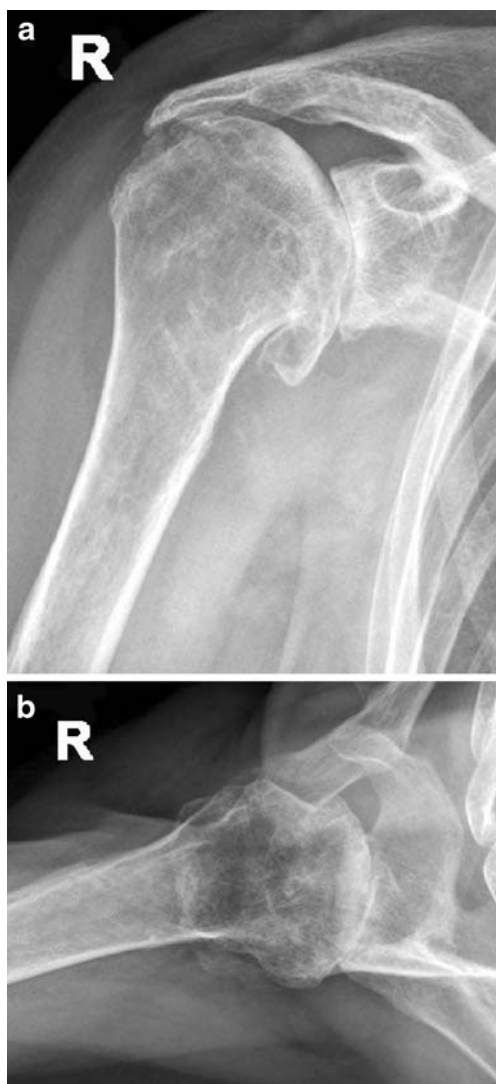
a, b Anteroposterior and axillary radiographs of a 72-year-old man with typical signs of an arthritic type I shoulder. The joint space is narrowed; the humeral head migrated cranially with acetabularisation of the coracoacromial arch and joint incongruency
